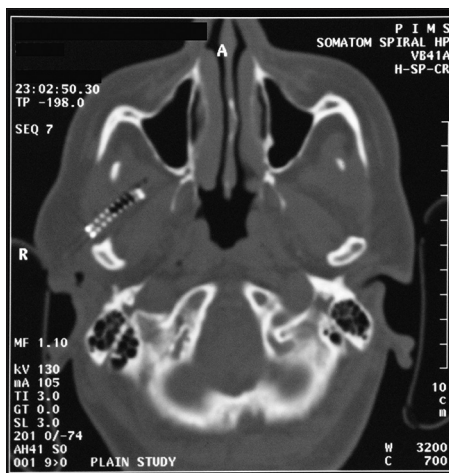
Computed tomography scan showing a 3 cm long spring in right infra temporal fossa
